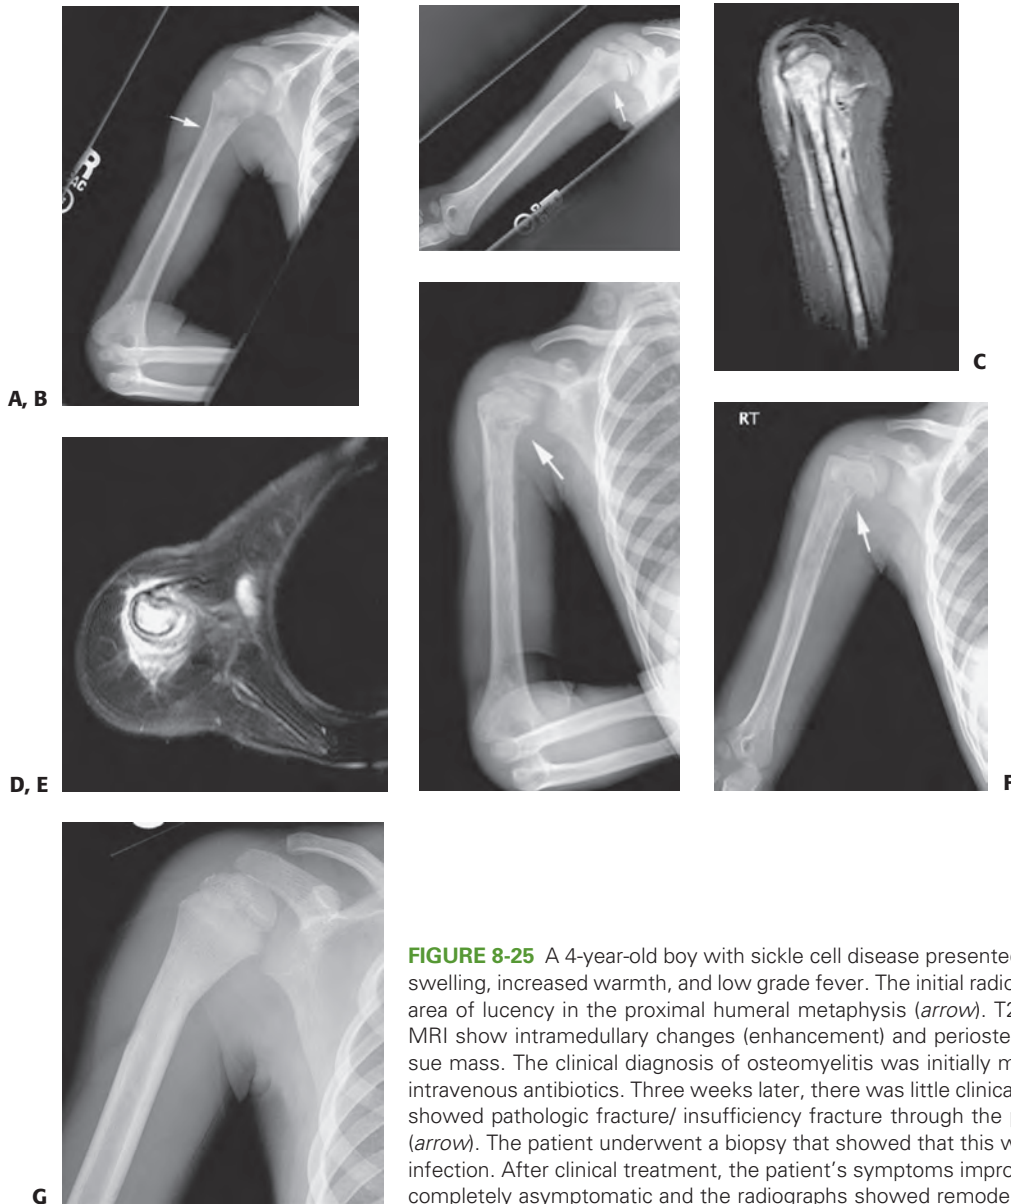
A 4-year-old boy with sickle cell disease presented with acute onset of right arm pain, swelling, increased warmth, and low grade fever. The initial radiographs (A, B) show a poorly defined area of lucency in the proximal humeral metaphysis (*arrow*). T2-weighted sagittal (C) and axial (D) MRI show intramedullary changes (enhancement) and periosteal reaction/abscess with no soft tissue mass. The clinical diagnosis of osteomyelitis was initially made and the patient was started on intravenous antibiotics. Three weeks later, there was little clinical improvement and new radiographs showed pathologic fracture/ insufficiency fracture through the proximal humeral metaphysis (E, F) (*arrow*). The patient underwent a biopsy that showed that this was an infarct with no superimposed infection. After clinical treatment, the patient's symptoms improved. At 6-months follow-up, he was completely asymptomatic and the radiographs showed remodeling and continued growth (G).
